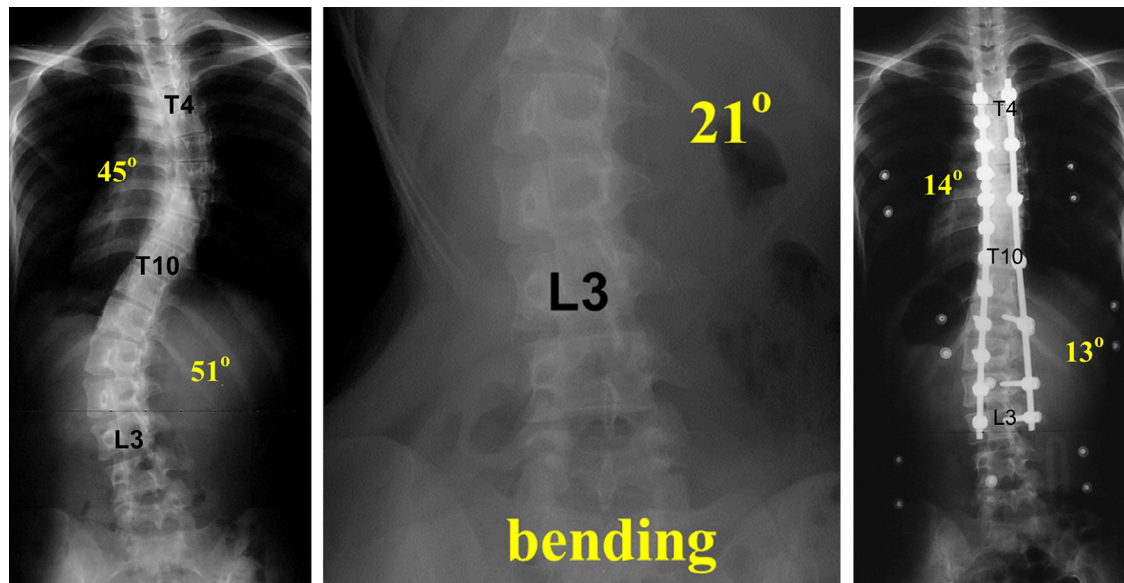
An example of distal fusion terminated at L3. (Left) The degree of rotation of L3 was Grade 2, based on the Nash and Moe classification. (Middle) The stable vertebra was found to be L3, as observed on bending radiographs. (Right) Fusion was achieved to L3 distally, as this case met the criteria.
